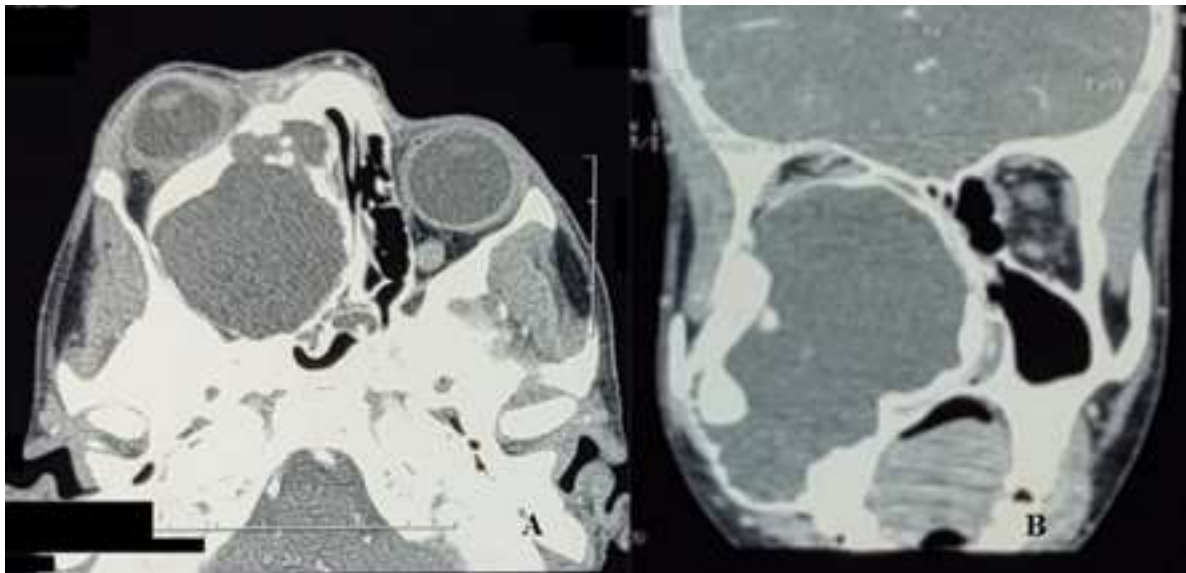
CT Scan of Nose and Paranasal Sinuses Showing (A) Cystic Lesion in the Right Maxillary Sinus With Intra Nasal Extension (B) Expansion of the Lesion in to the Orbit With Right Eye Proptosis
